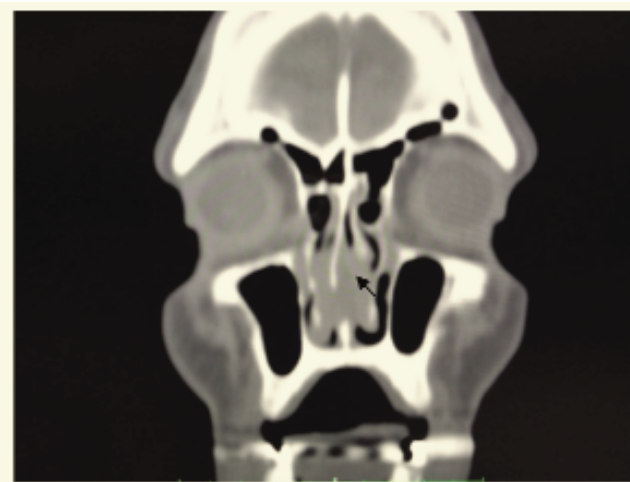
Coronal computed tomography scan of the paranasal sinuses revealing nasal septal abscess (arrow) and unremarkable maxillary, ethmoidal and frontal sinuses.
